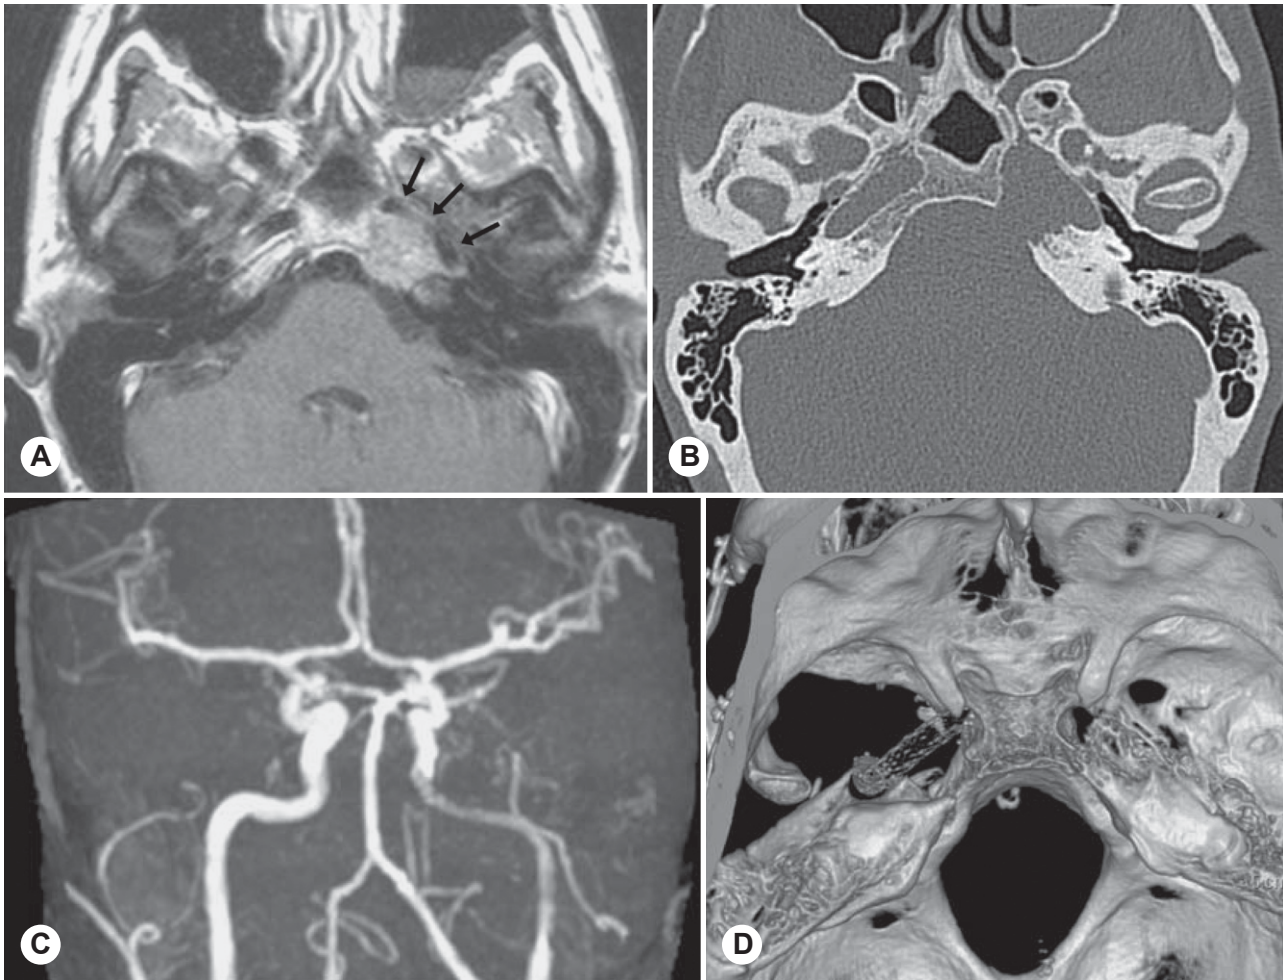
(Patient 11) A) Axial T1-weighted magnetic resonance image with gadolinium enhancement shows left chondrosarcoma involving petrous apex. Internal carotid artery lumen (arrows) is narrowed. B) Axial high-resolution computed tomographic scan of same lesion shows erosion of horizontal portion of carotid canal. C) Magnetic resonance angiogram with maximum-intensity projections demonstrates narrowing of cervical and petrous portions of internal carotid canal. D) Three-dimensional shaded surface display reconstruction from computed tomographic scan shows surgical defect that resulted from infratemporal type B approach. Note mesh of stent inside internal carotid artery.
